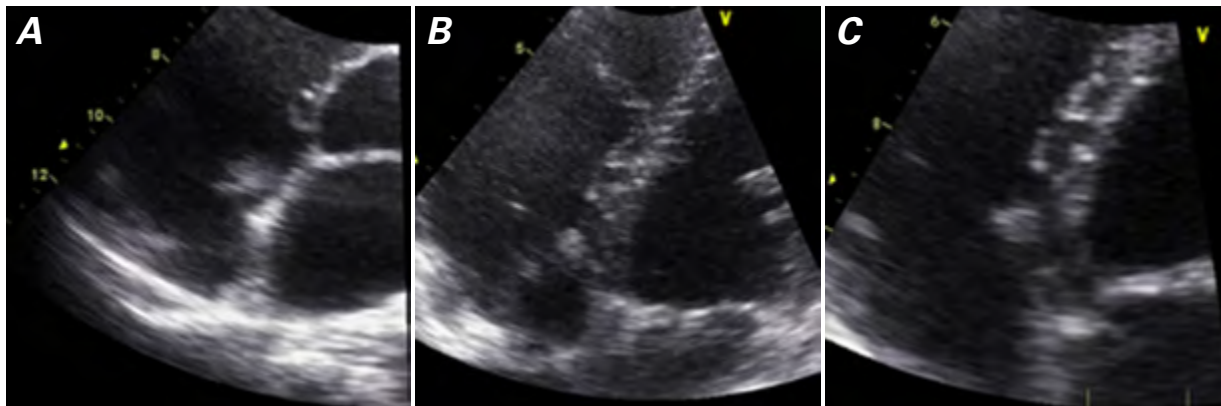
Two-dimensional echocardiograms show the 10 × 5-mm vegetation on the septal leaflet of the tricuspid valve in A) parasternal short-axis view, B) modified apical 4-chamber view, and C) magnified modified apical 4-chamber view.
